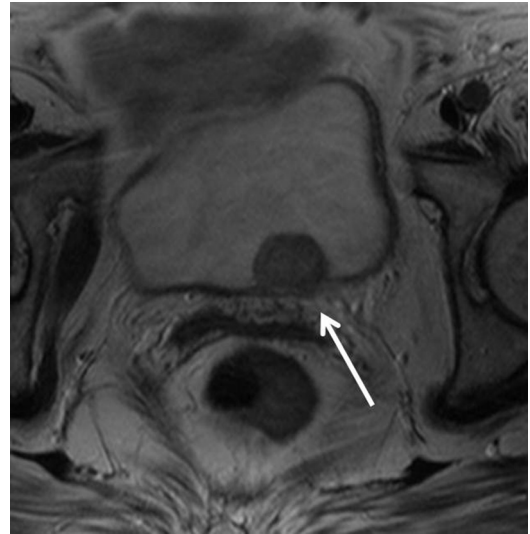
T2-weighted axial image. There is interruption of low signal muscular wall of the bladder (*arrow*) in keeping with T2 tumor.
